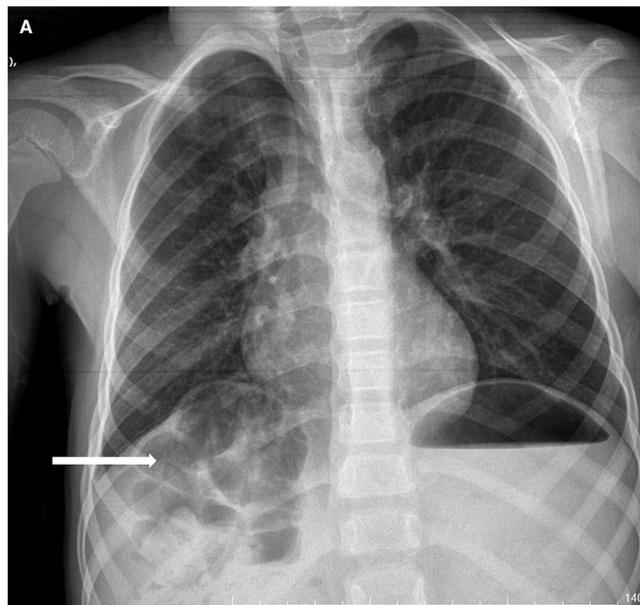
A, Plain abdominal radiograph showed gas between liver and diaphragm. B, Colonic interposition was observed at anterior of the liver.
